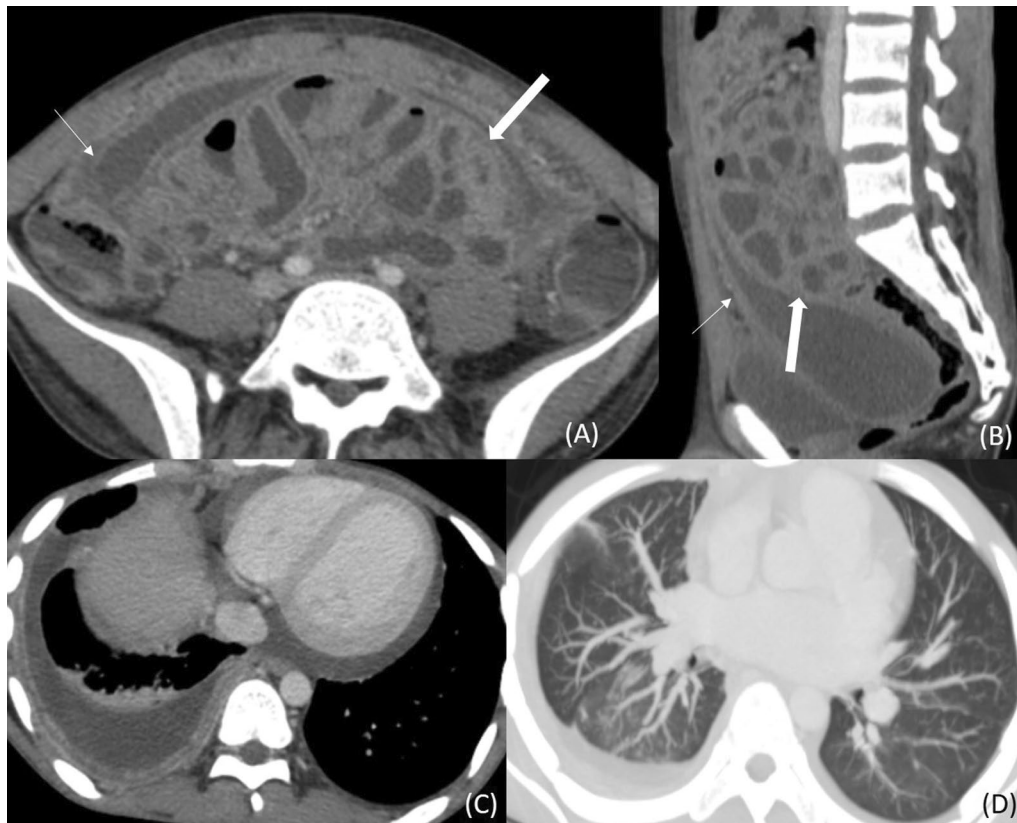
Abdominal cocoon. Abdominal CT images of 23-year-old male show clumping of small bowel loops in centre of abdominal cavity surrounded by thick and enhancing membrane (solid arrow in A, B), there is gross ascites and thickening of peritoneal membrane (thin arrow in A, B), thorax CT shows pericardial effusion and right pleural effusion with thickening of parietal pleura, suggestive of empyema (C) and lung window shows randomly distributed nodules in the right lower lobe (D)
